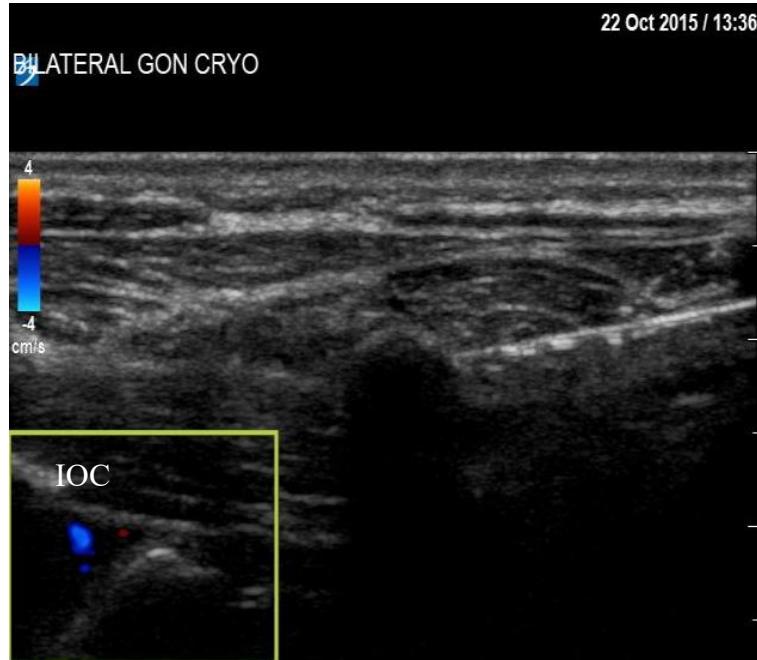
The vertebral artery is in the trajectory of the needle; however, the artery is beneath the IOCM, far lateral to our target, and usually well visualized by 2- dimensional and color Doppler mode. Image courtesy of Agnes Stogicza MD.
